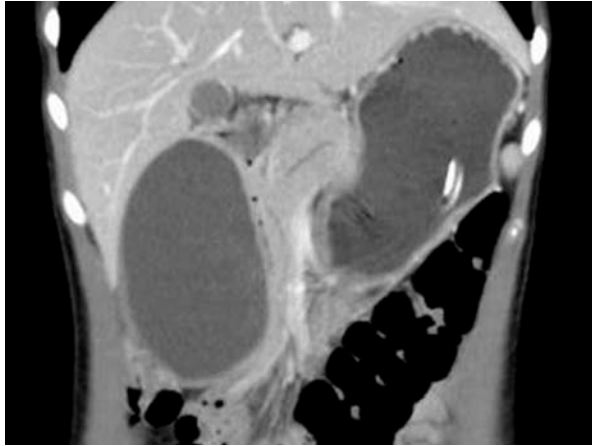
A contrast enhanced CT scan of the abdomen showing a well defined thin walled fluid filled cyst measuring 9.6 x 5.6 x 5.5 cm in the right sub-hepatic area.
